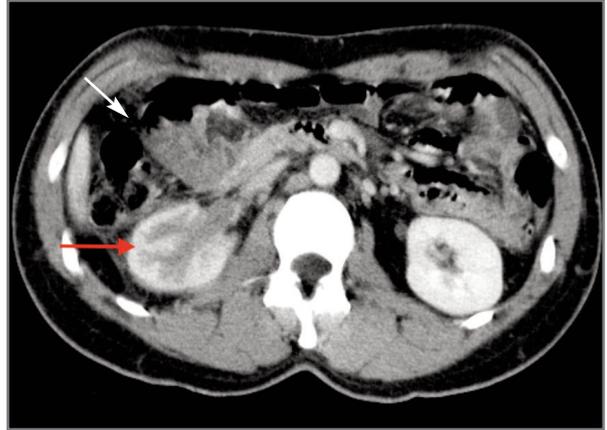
CT: Almost complete regression of the mass. Densification of peri-renal fat and thickening of the urothelium (red arrow) can be observed.
